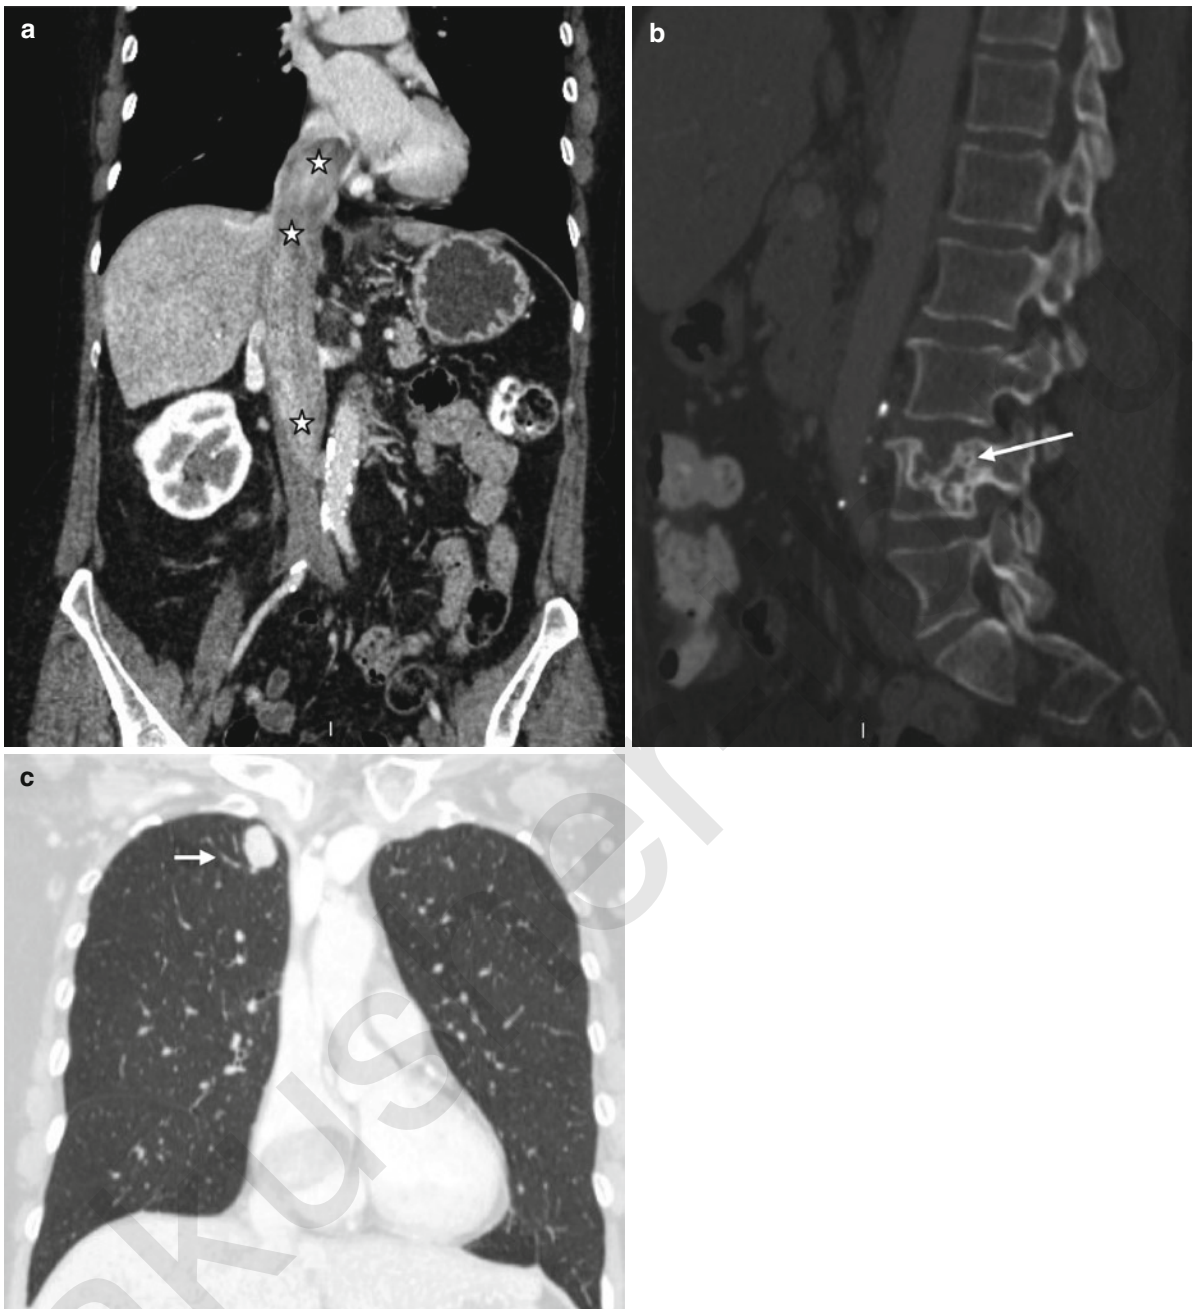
Low grade endometrial stromal sarcoma resected with TAH and BSO 29 years previously. (a) CT scan post contrast: recurrence of extensive venous tumour thrombus in pelvic veins, IVC, and extending to right atrium (*stars*) (note vascular
